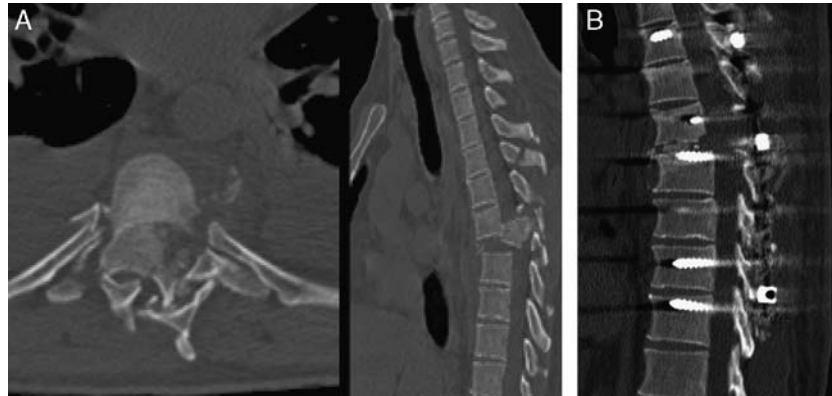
A, A 48-year-old man, who fell 6 meters while working, presented with T7 fracture and T6-T7 dislocation. Preoperative CT scan showing the fracture-dislocation and expulsion of the T7 vertebral body into the spinal canal. B, T7 vertebrectomy and spine shortening were carried out 8 days after the accident. Immediate postoperative CT scan showing good segmental alignment and close apposition of the endplates of T6 and T8. CT indicates computed tomography.
